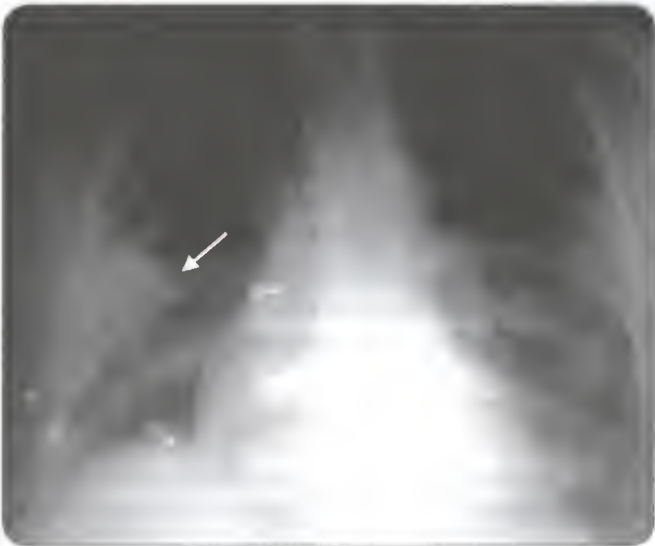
Chest X-ray showing wedge shaped pulmonary infarct
